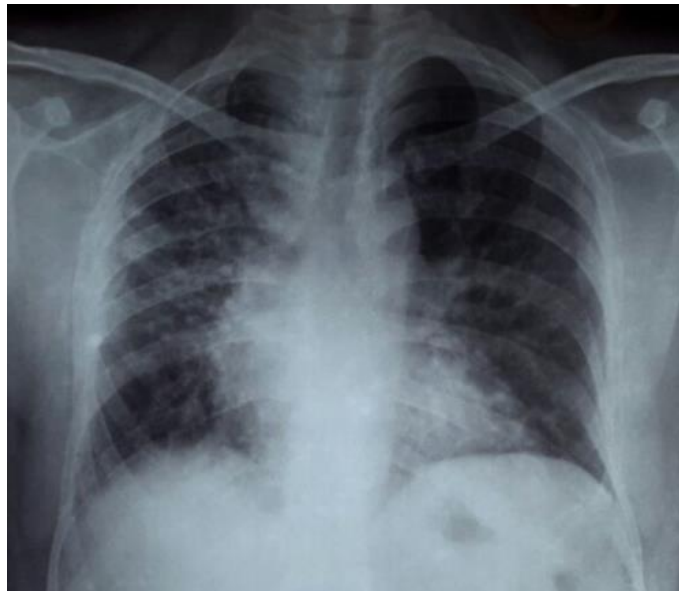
Chest Xray- Right mid zone bronchiectatic changes with compensatory hyperinflation of left lung.
